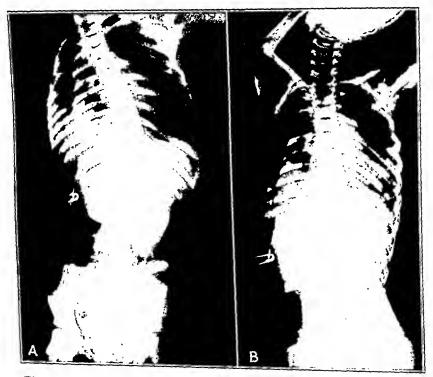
A child of 7 years with chronic empyema and an early pleural scoliosis: A, roentgenogram taken with the patient standing, and B, roentgenogram taken with the patient lying and undergoing postural wedging.
